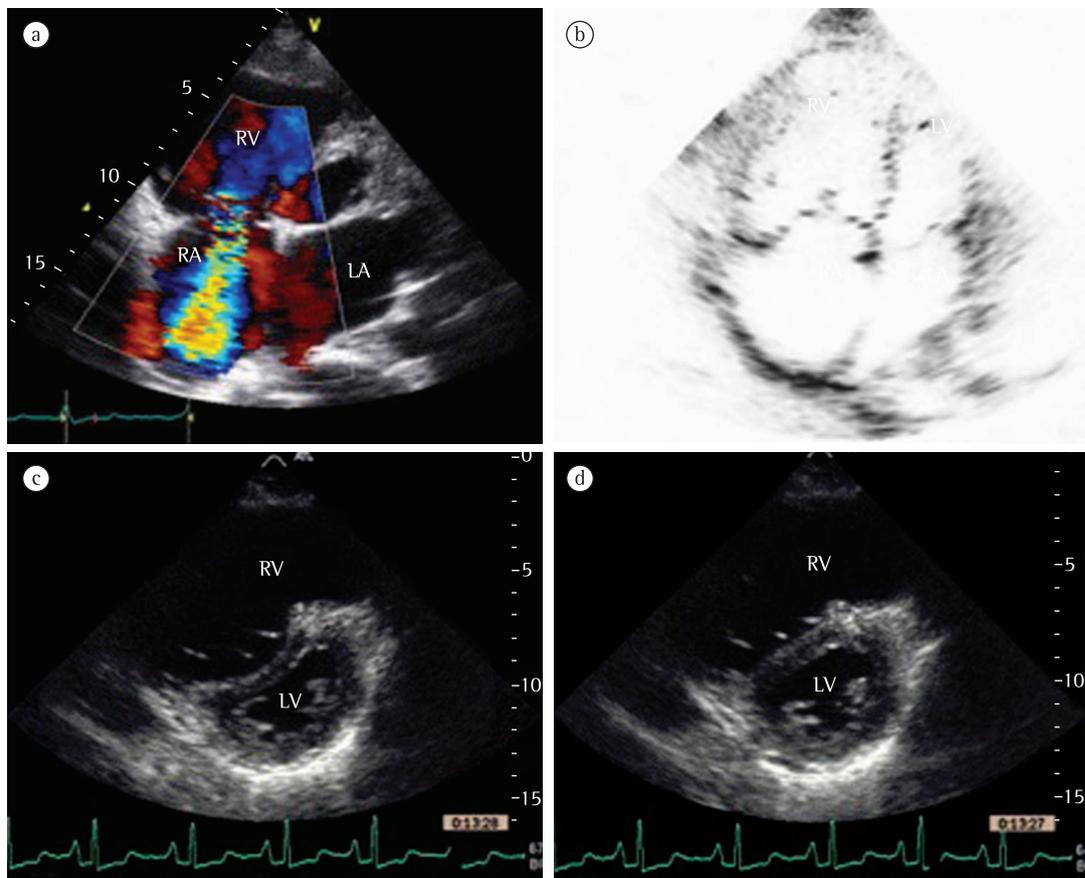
Echocardiography images. Note the intensity of the continuous wave Doppler signal of the tricuspid regurgitant jet during ventricular systole (in a) and the dilated right heart (in b). Note the pressure overload in the right ventricle (RV), leading to paradoxical interventricular (IV) septal motion to the left, and the reduction in the size of the left ventricle (LV) during diastole (in c). During ventricular systole, the IV septum remains flattened (in d). Imaging provided by Dr. Fabio Lario, attending physician in the Department of Echocardiography of the Heart Institute of the University of São Paulo School of Medicine *Hospital das Clínicas*.
